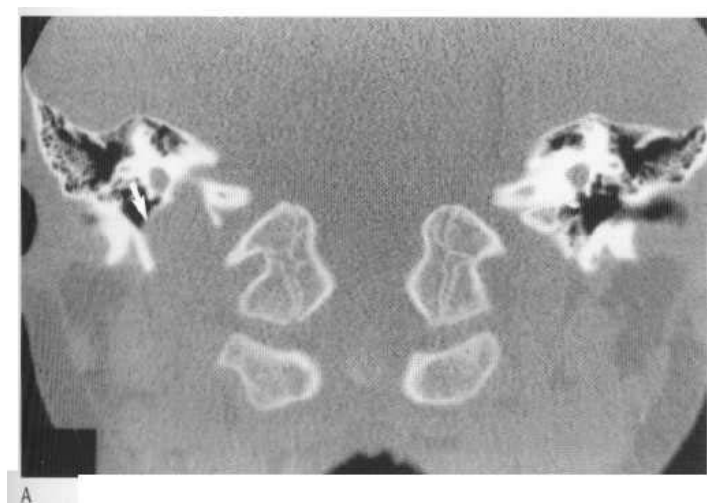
(A) Coronal CT section showing high jugular fossa on one side with diverticulum. The arrow points to the thin bone separating the jugular bulb from the hypotympanum of the middle ear. (B) MRA shows the large jugular bulb (arrow).
